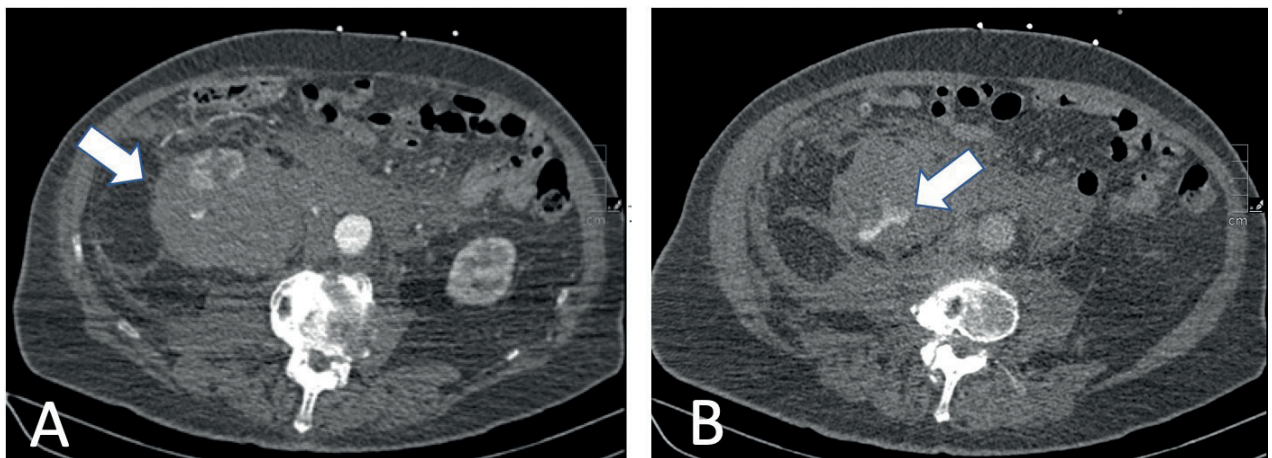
Contrast CT showing the large subcapsular right renal haematoma with blush of contrast in the arterial phase (arrow in A), increasing in the venous phase (arrow in B), consistent with active bleeding.
